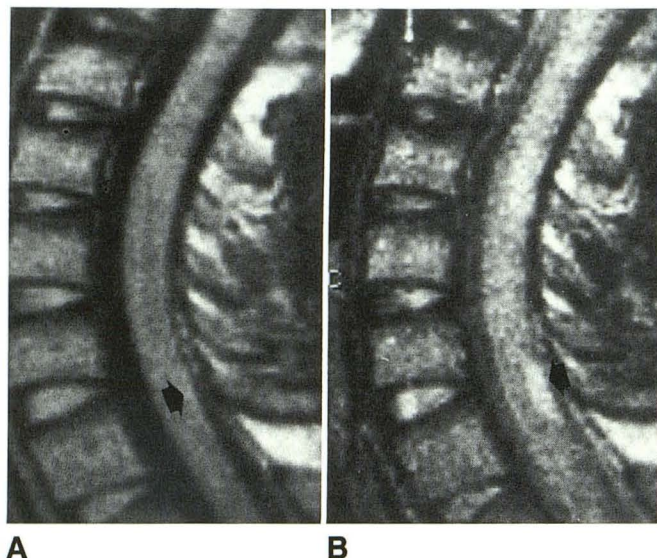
A, T1-weighted sagittal MR examination (1000/40) shows an ill-defined, subtle increased signal intensity (arrow).
